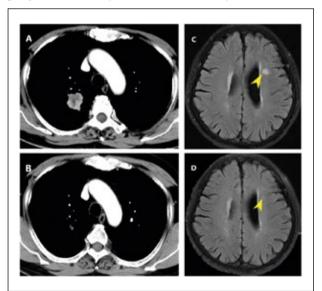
Computed tomography and magnetic resonance imaging findings before and after treatment with alectinib. Before treatment, computed tomography scan revealed (a) a tumor in the upper lobe of the right lung, and magnetic resonance imaging revealed (c) brain metastases(arrow). A computed tomography scan 6 months after commencing treatment revealed (b) a dramatic reduction in tumor size and magnetic resonance imaging revealed (d) almost no brain metastasis (arrow).
